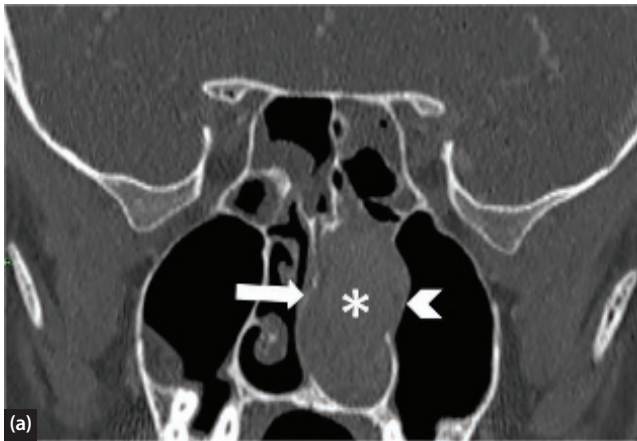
(a) Coronal CT. Juvenile nasopharyngeal angiofibroma (asterisk) extending into the choana with obstruction of the left nasopharynx, bowing of the vomer to the right (arrow) and bowing of the medial wall of the left maxillary antrum (arrowhead). (b) Axial CT. Bone windows showing erosion of the vomer (thick arrow), destruction of the pterygoid (arrowhead) and extension into the pterygopalatine fossa (thin arrow). Images courtesy of Dr S Goodwin, Consultant Paediatric Radiologist, Royal Hospital for Children, Glasgow.
